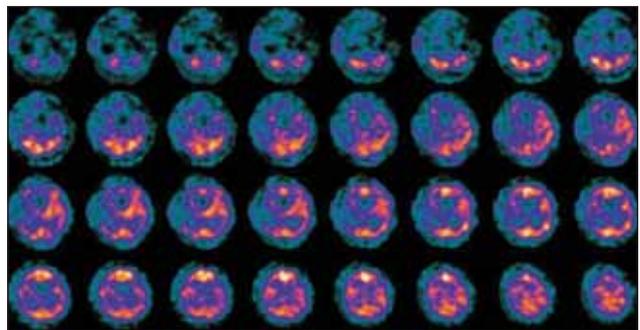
Transaxial brain perfusion ^{99m}Tc -HMPAO SPECT images taken during the acute phase. Cerebral cortical HMPAO uptake is heterogenous and globally decreased in the right cerebral hemicortex. Severe hypoperfusion is present in right frontoparietal, parietal, parietotemporal, parietooccipital cortical regions, and the right thalamus. There is also mild hypoperfusion in the basal ganglion. Hypoperfusion observed in left cerebellar hemisphere is compatible with crossed cerebellar diaschisis.
